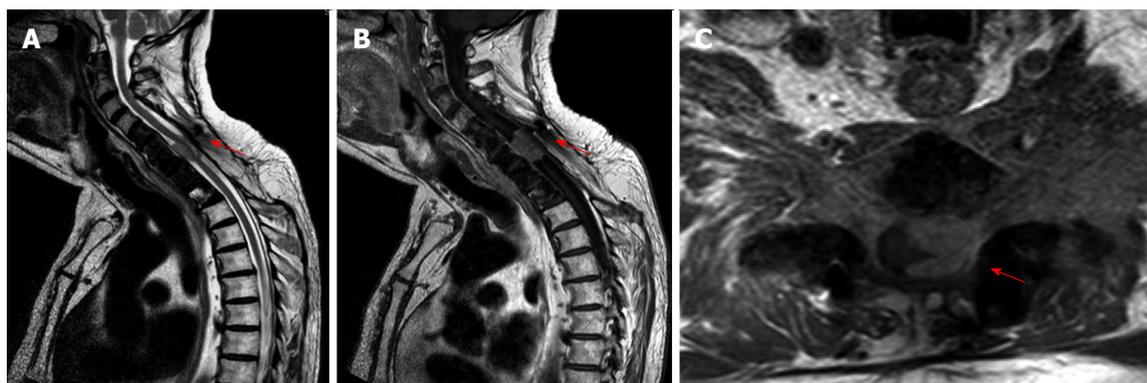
Cervical spine magnetic resonance imaging. A: A C5-C7 lesion with homogeneous enhancement after gadolinium administration in the T1-weighted sequences; B: T2 weighted sequences showing the enclosed spinal cord; C: Especially on the left side (red arrow).
